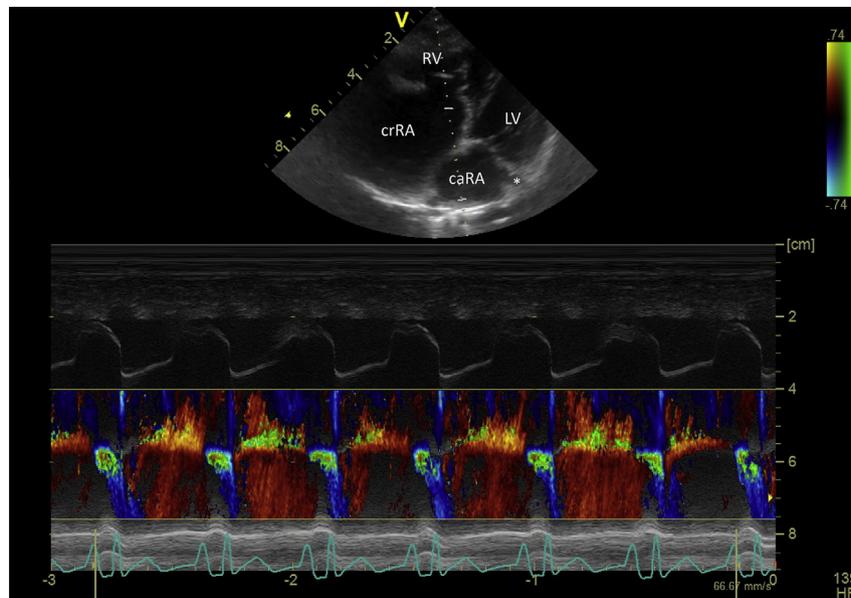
Two-dimensional and color Doppler M-mode echocardiographic image from the left apical imaging window. Bidirectional flow across the cor triatriatum membrane is demonstrated here with reversed flow from the cranial right atrium (crRA) to the caudal right atrium (caRA) during atrial contraction (blue signal) and typical flow from caRA into the crRA throughout the remainder of the cardiac cycle (red signal). RV, right ventricle; LV, left ventricle. *Dilated coronary sinus.
